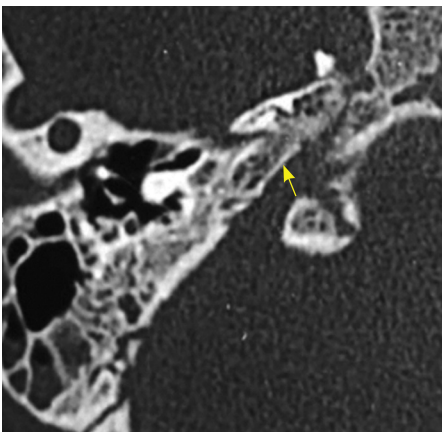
HRCT temporal bone, axial section, bone window shows CLA without otic capsule with presence of petrous bone (yellow arrow).
